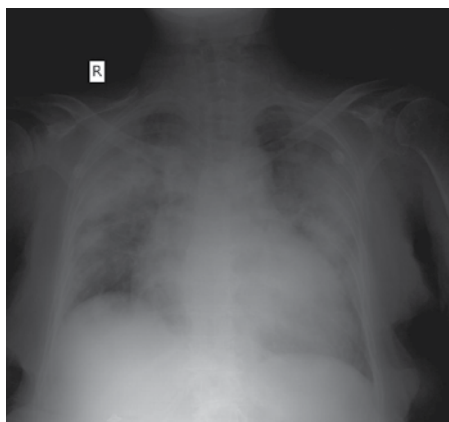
Chest X-ray revealed diffuse infiltrates in both lungs
